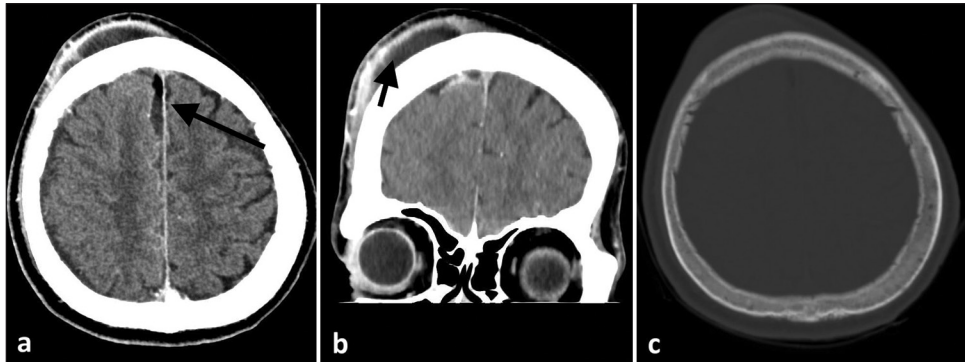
(a) The contrast-enhanced axial CT scan revealing a subdural fluid collection in the adjacent right frontal convexity (Long arrow), (b) A rim-enhancing subgaleal fluid collection in the right frontal region (Short arrow), (c) No bone destruction present at the first scan.
